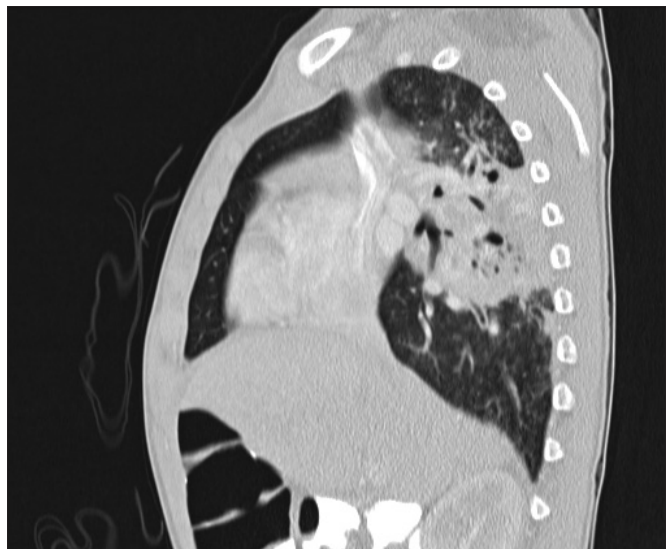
Computed tomography image with the mass-like opacification in the superior segment of the right lower lobe, and in close proximity to the oesophagus.
